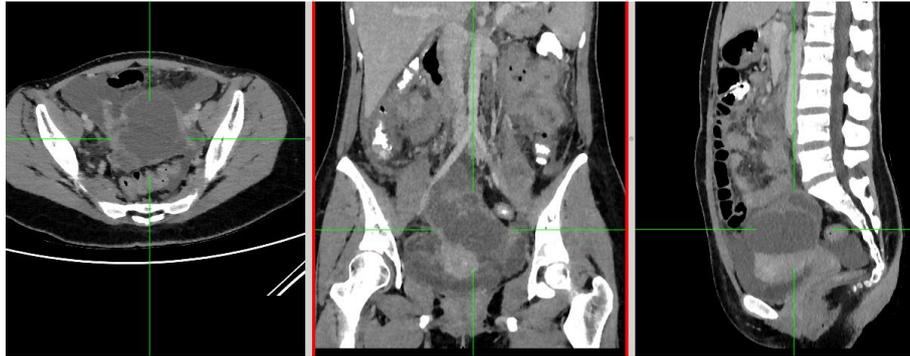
Endometrioid carcinoma, 60 y. o woman with CA 125 level 8749.5 U/ml. CT scan feature showed cystic, with solid component, septic, irregular wall, contrast enhanced, ascites, peritoneal carcinomatosis.
